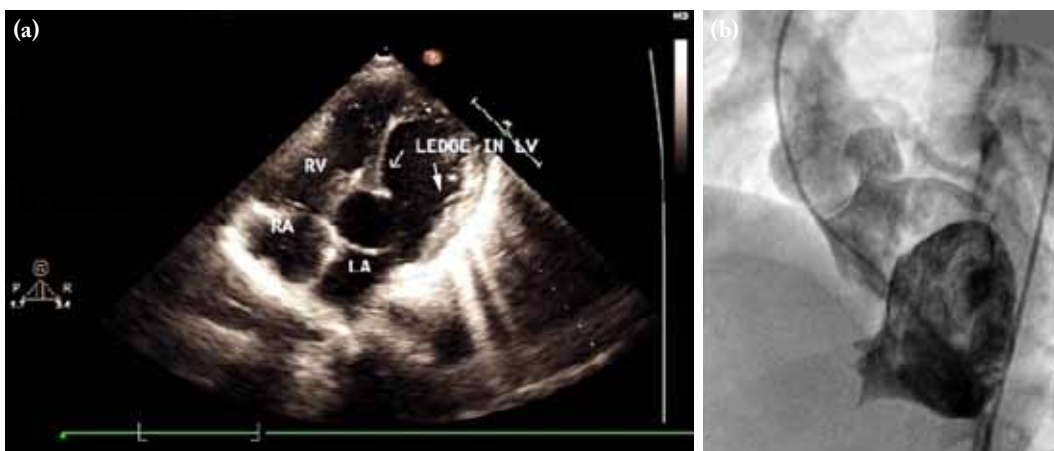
A preoperative echocardiogram and angiogram view. (a) Transthoracic echocardiogram showing ledge of tissue from both the wall of the left ventricle, more from the septal wall, producing double-chambered left ventricle. (b) Left ventriculography showing double-chambered left ventricle with possibly closed apical ventricular septal defect.
